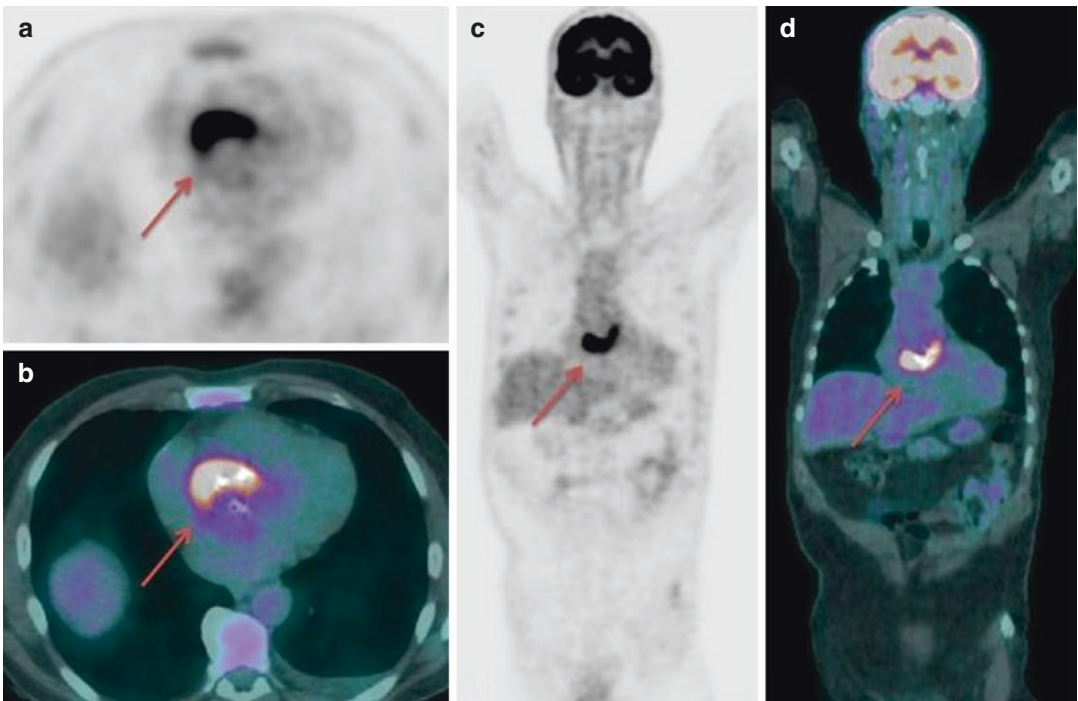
A 57-year-old patient with prosthetic valve endocarditis: axial PET (a) and PET/CT (b) views, coronal PET (c) and PET/CT (d) views show high ¹⁸F-FDG
